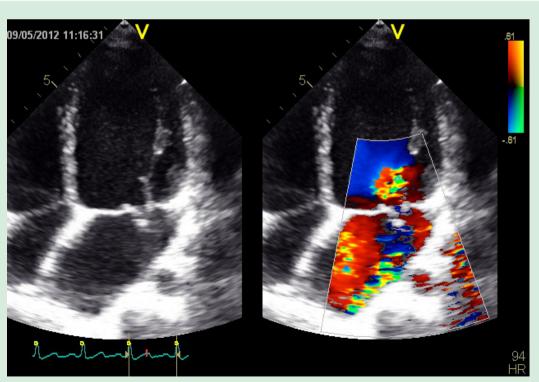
Apical four-chamber view with color flow mapping, revealing significant mitral regurgitation secondary to partial rupture of the anterolateral papillary muscle and flail of anterior leaflet.
